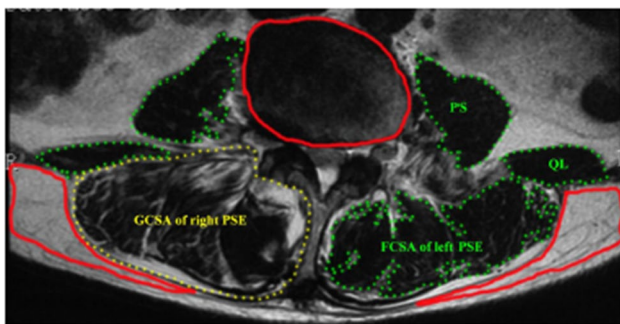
Measurement of paraspinal muscular parameters on MRI. The functional cross-sectional area (FCSA) of psoas muscle (PS), quadratus lumborum (QL) and left paraspinal extensor muscles (PSEs, including multifidus [MF] and erector spinae [ES]), were outlined by green dotted lines. Regions of intervertebral disc and muscle-subcutaneous fat were outlined by red solid lines. For right PSEs, gross muscle was outlined on the right side by yellow dotted line
